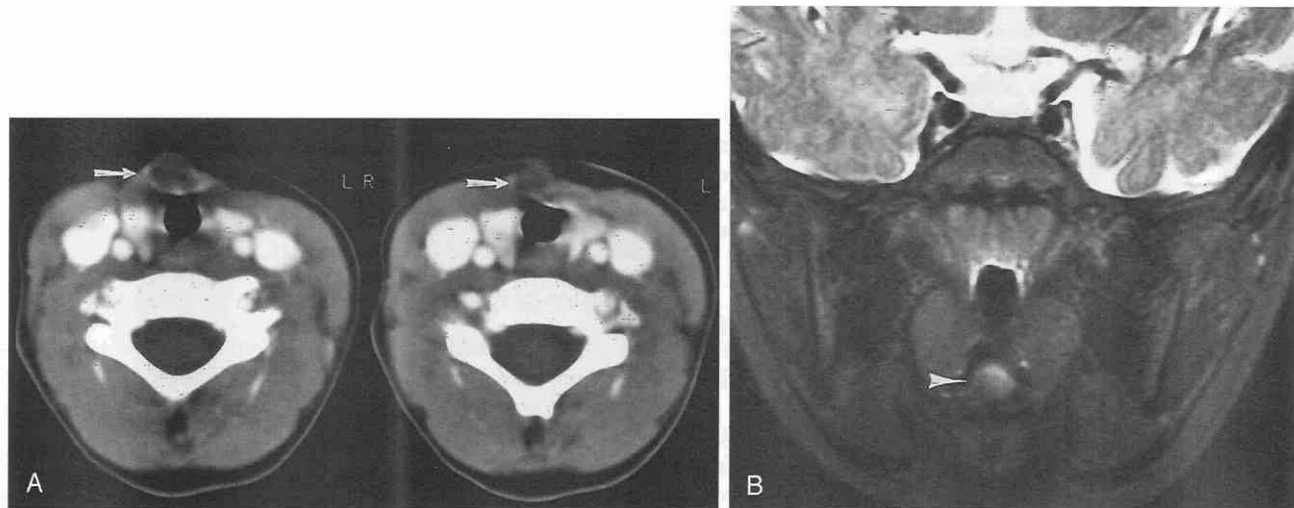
Thyroglossal duct cyst. A, Axial postcontrast CT scan demonstrates a midline mass of decreased attenuation (arrows) at the level of the thyroid gland. Minimal rim enhancement is present. B, Coronal fast spin-echo (FSE) MRI scan shows an oval-shaped mass of slightly hyperintense signal at the base of the tongue, in the area of the foramen cecum (arrowhead) in this infected cyst.
